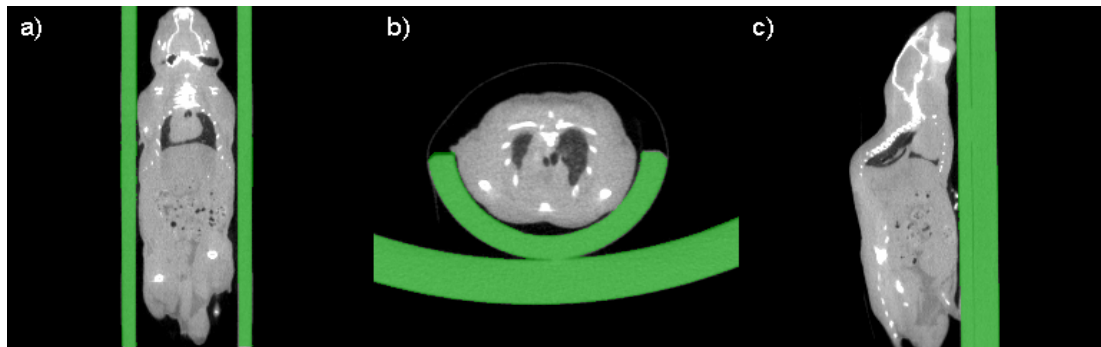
The CT images with segmented holder. The holder is segmented automatically *via* a registration procedure.
